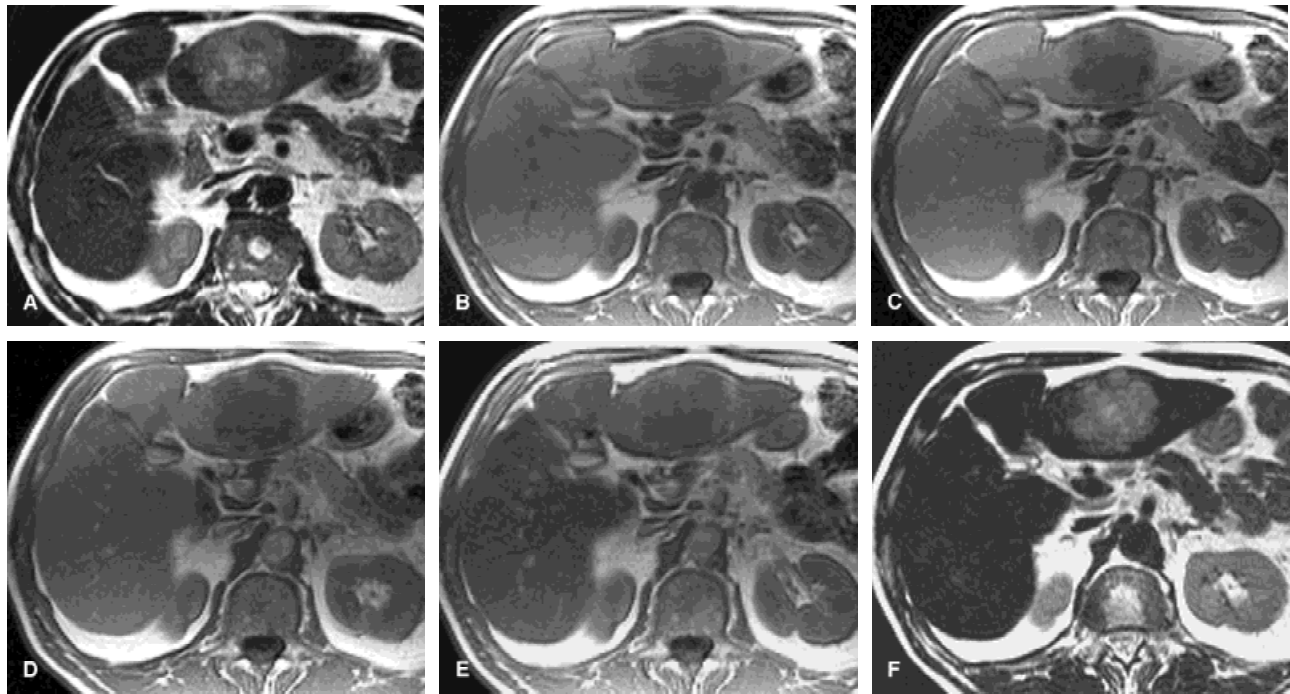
Peripheral cholangiocarcinoma in a 62-year-old man. a: TSE transverse T2-weighted image shows a large hyperintense lesion in the left lobe of the liver. b: GRE transverse T1 precontrast image. The lesion is homogeneously hypointense to the surrounding liver parenchyma. During dynamic imaging with bolus administration of SH U 555 A (GRE transverse T1-weighted), the lesion does not show any significant enhancement in the arterial (c) and portal venous phases (d). e: GRE transverse T1-weighted images obtained 10 minutes after administration of SH U 555 A. Slight enhancement of the liver parenchyma at the margins of the lesion is seen. e: TSE transverse T2-weighted images obtained 10 minutes after administration of SH U 555 A. Homogenous signal drop of the liver parenchyma augments the contrast between the liver and the lesion.
